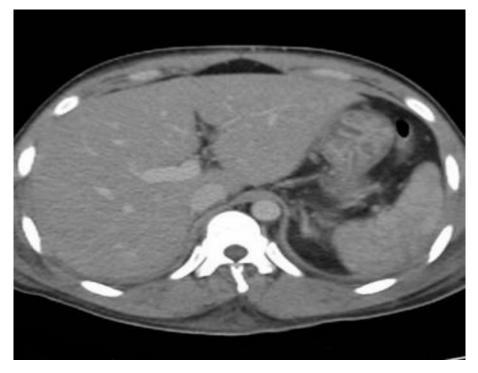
Axial abdominal CT scan of SCD patient shows hepatomegaly with homogeneous contrast enhancement is seen in the portal venous phase.
